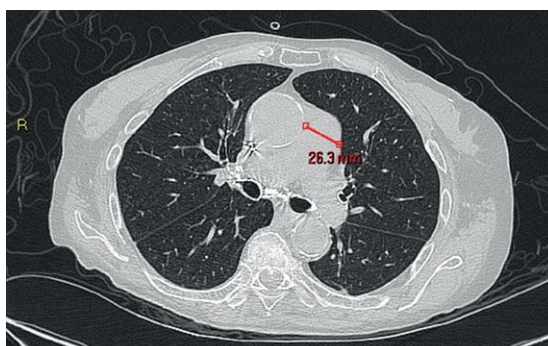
Control CT scan showing complete regression of the lesions.
